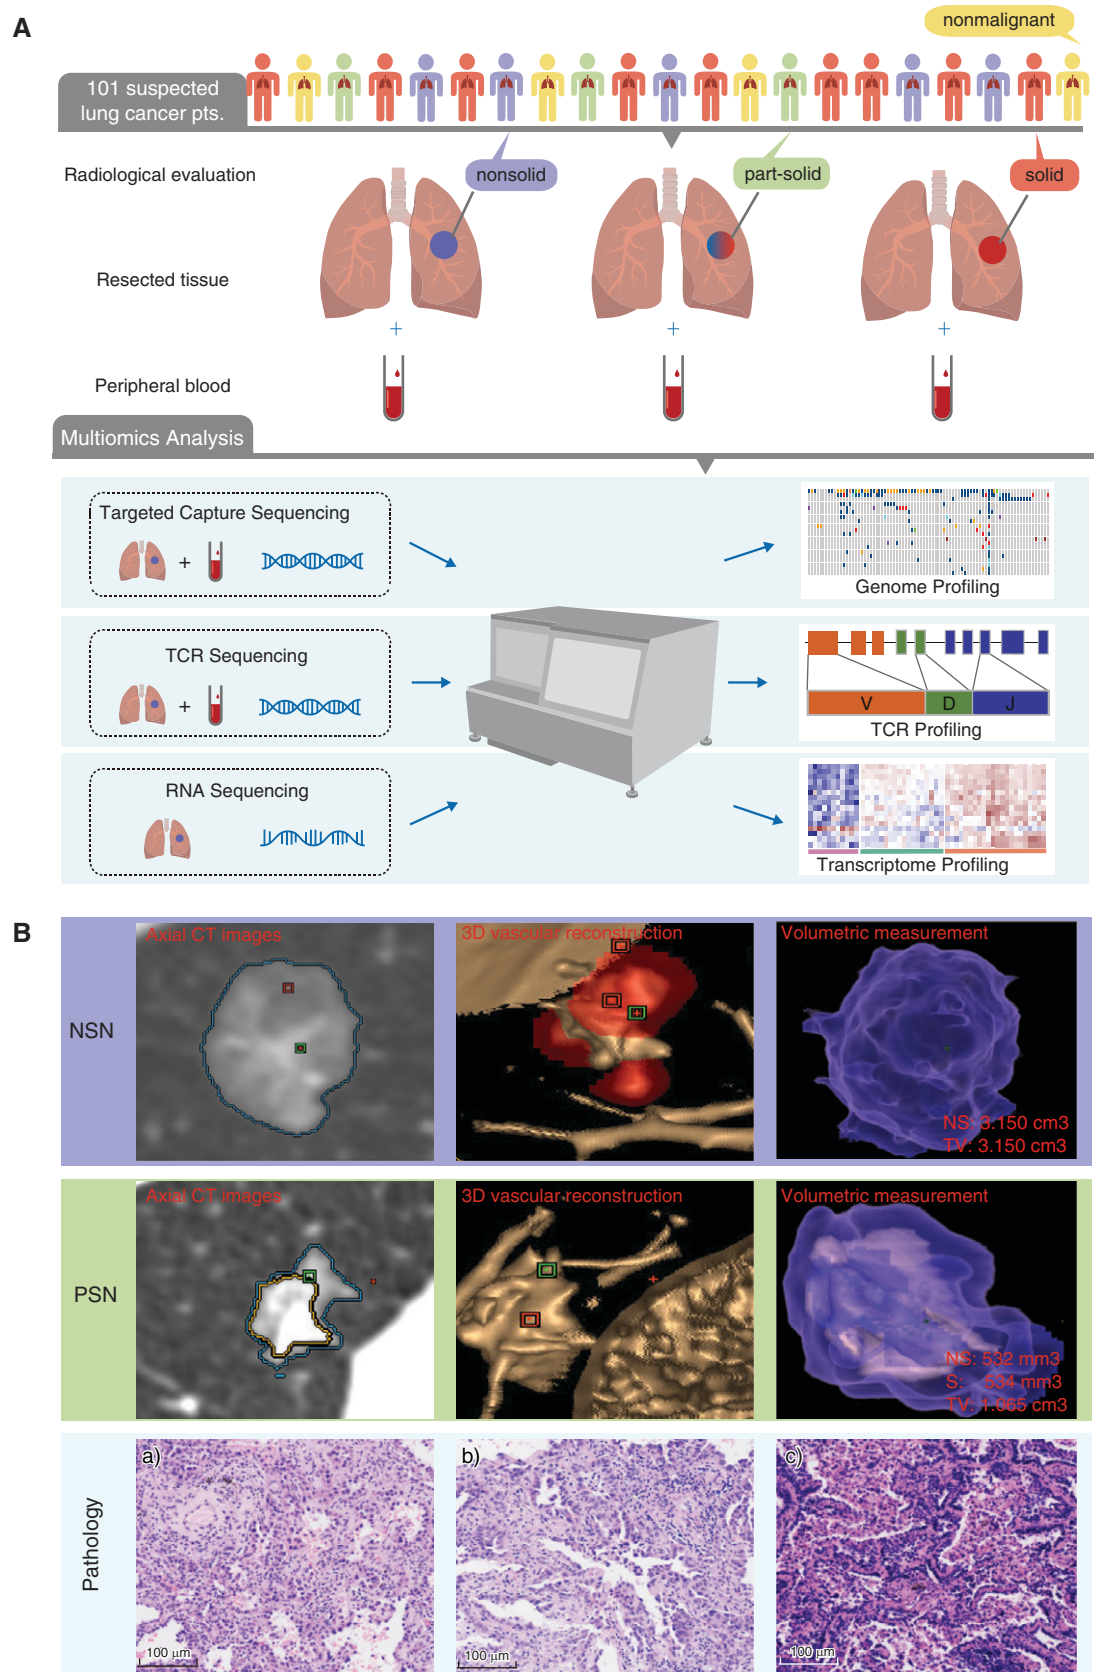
Research strategy. (A) Description of sample collection and multiomics analysis. (B) Example axial CT images, 3D vascular reconstruction, and volumetric measurement for one nonsolid nodule (NSN) and one part-solid nodule (PSN) (50%). The ground-glass opacity
